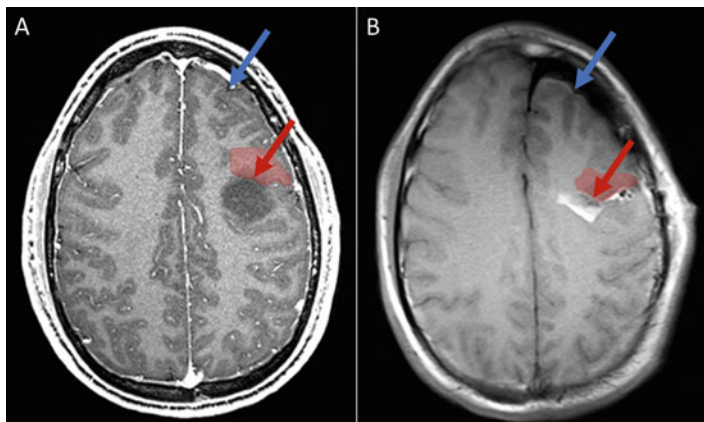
(a) Pre-operative MRI showing a brain tumour (dark region). (b) Intra-operative MRI (iMRI) after near-complete resection with significant brain shift. Brain shift significantly reduces the validity of neuronavigation from pre-operative data. Brain shift can occur far from the surgical site (in blue). More clinically relevant, it can cause significant deformation and displacement near margins of the resection cavity (in red), precisely where surgeons could most benefit from accurate image guidance
